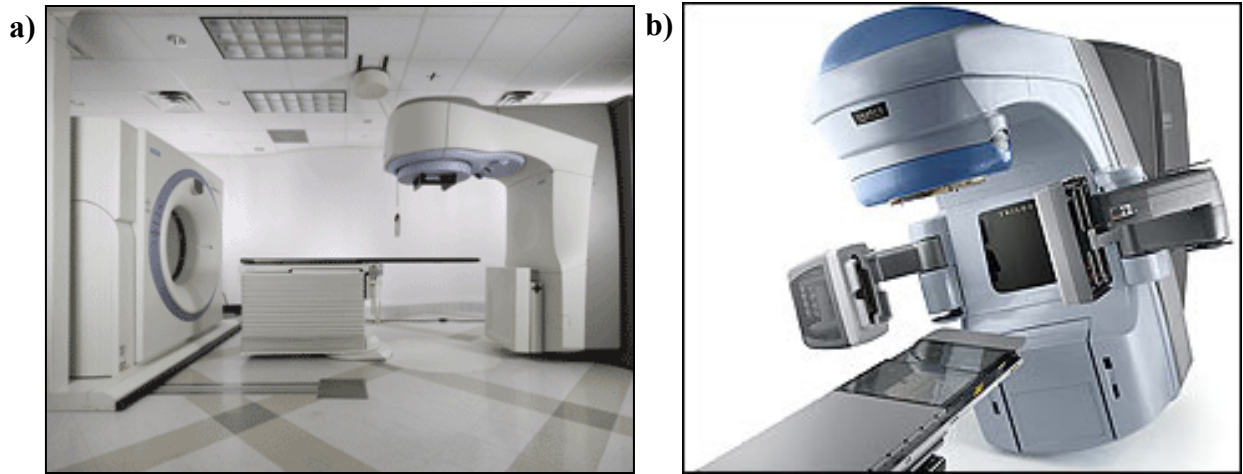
Integrated treatment/imaging systems allow imaging the patient in treatment position: a) Linac/CT-on-rails system (image from [medical.siemens.com](http://medical.siemens.com)), and b) Linac/Cone Beam CT (CBCT) system (image from [varian.mediaroom.com](http://varian.mediaroom.com)).
